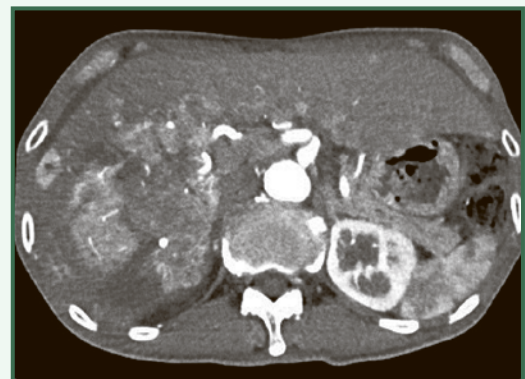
Contrast CT show Multifocal HCC with tumor necrosis. Right portal vein was itruncated by tumor thrombus
